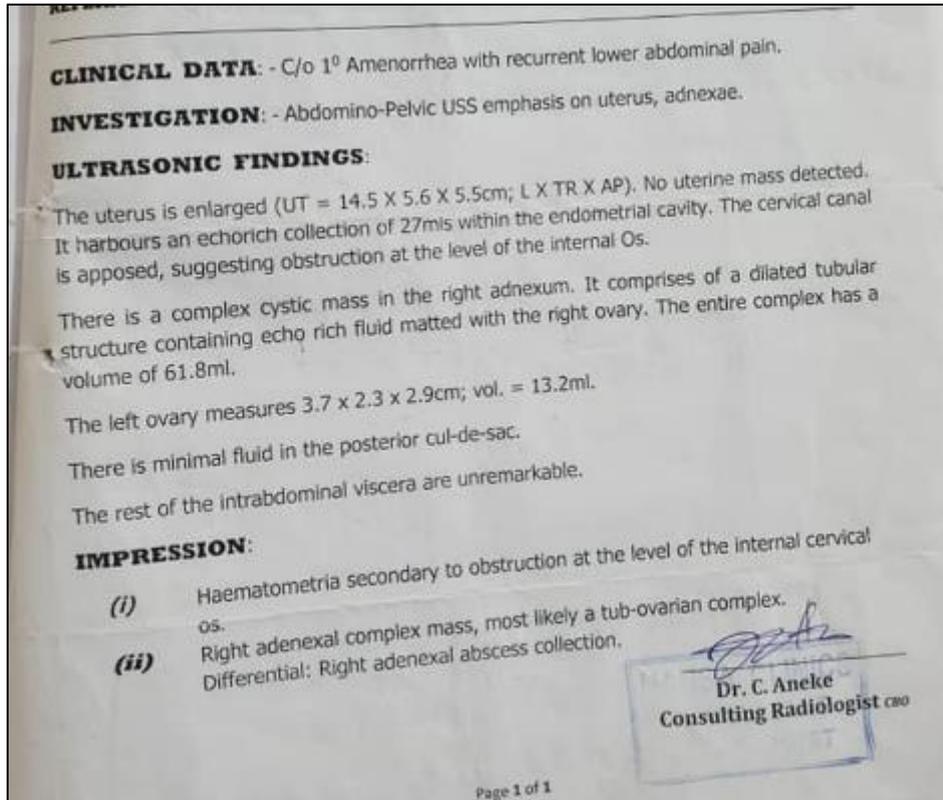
Abdominopelvic ultrasound scan
